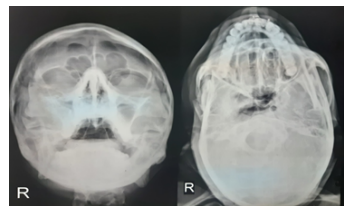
X-RAY SKULL SUBMENTOVERTICAL AND OCCIPITOMENTAL VIEWS SHOWING FRACTURE ZYGOMA®
